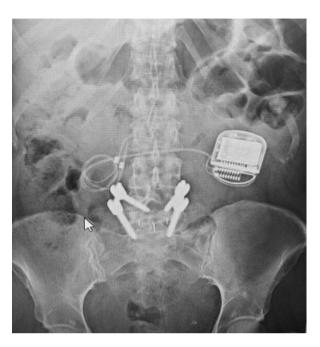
X-ray of IPG in flank site, above the iliac crest and below the last rib
